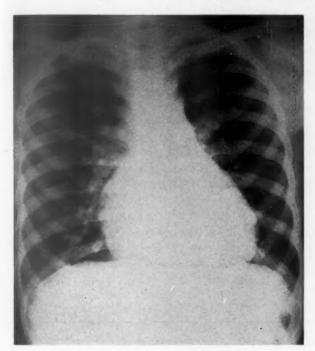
Case 2. The chest roentgenogram shows a globular, diffusely enlarged heart. The main pulmonary artery segment is prominent and there is a striking increase in the pulmonary vascularity.
